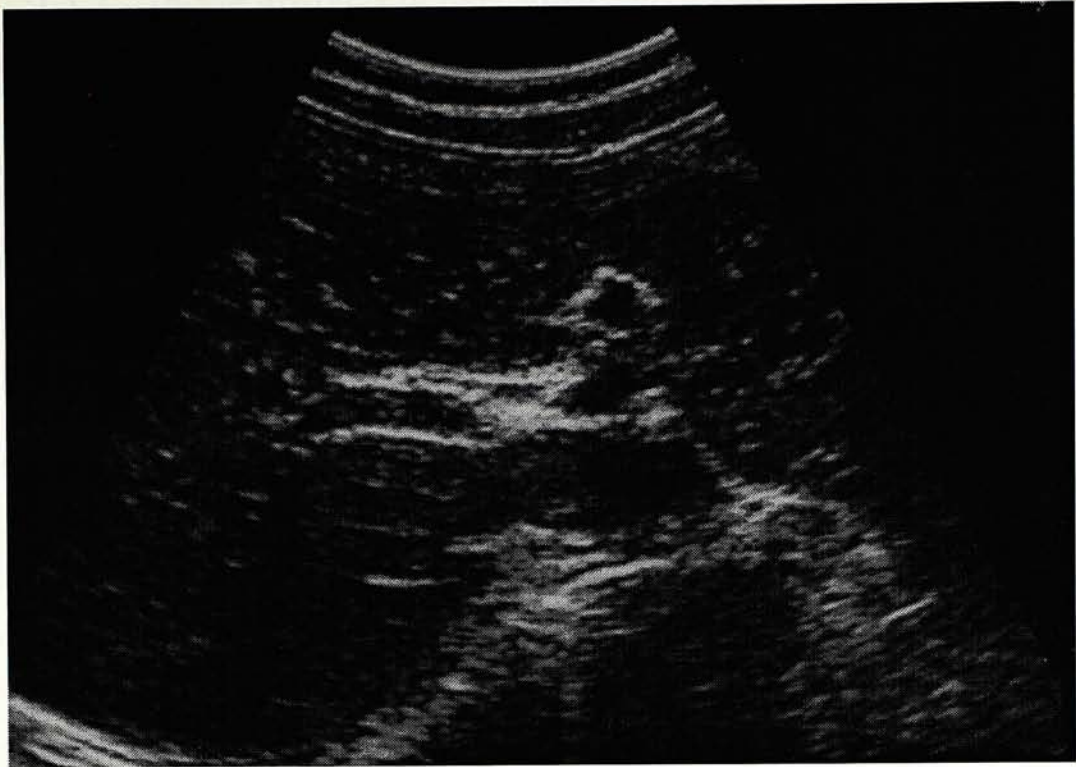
An ultrasonic image of the normal liver
